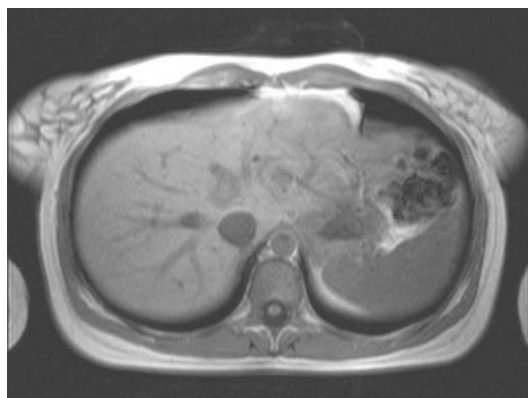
Transverse T1-weighted spoiled gradient echo liver image. *TR*, 142 ms; *TE*, 4 ms; excitation angle, 70°.
